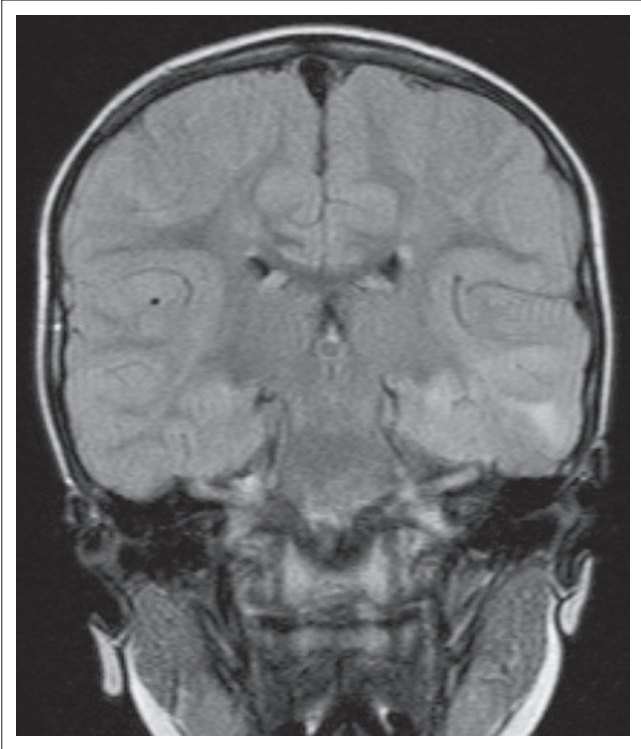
Coronal FLAIR MR image.
